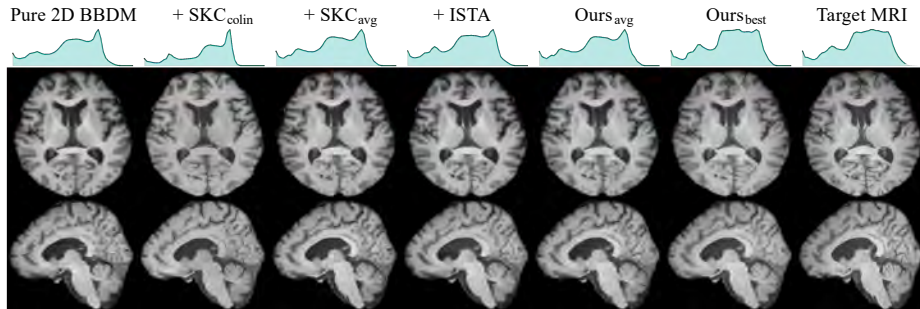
Qualitative comparison with baselines (CT→MRI)
